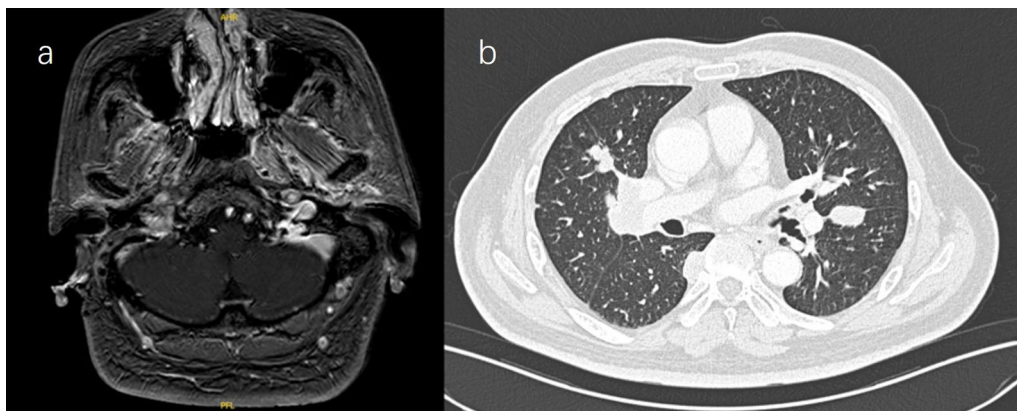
Magnetic resonance imaging reveals stable lesions at the apex of the petrous part of the temporal bone (a); thoracic computed tomography imaging indicates multiple bilateral pulmonary nodules with increased size (b)
